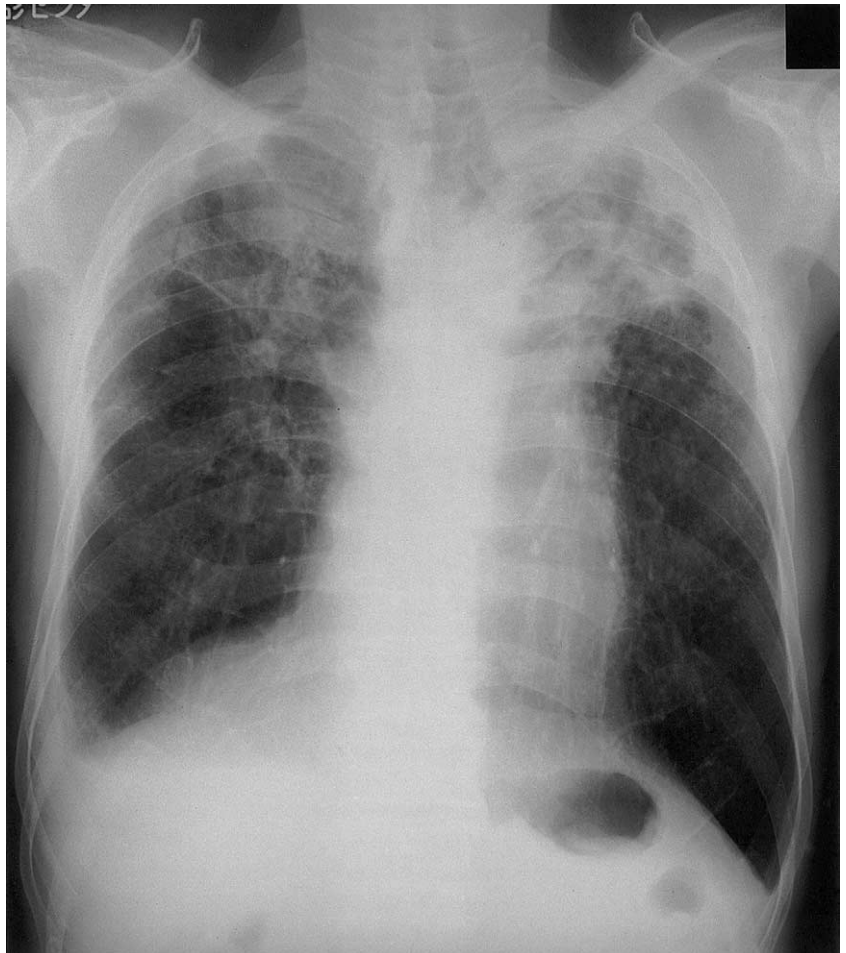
Chest radiograph of an 82-year-old male patient who had been working in a copper mine for 24 years, showing a small number of micronodules distributed in the bilateral upper and middle lung fields. Egg-shell-type calcifications are noted in the tracheobronchial and supraclavicular lymph nodes.
